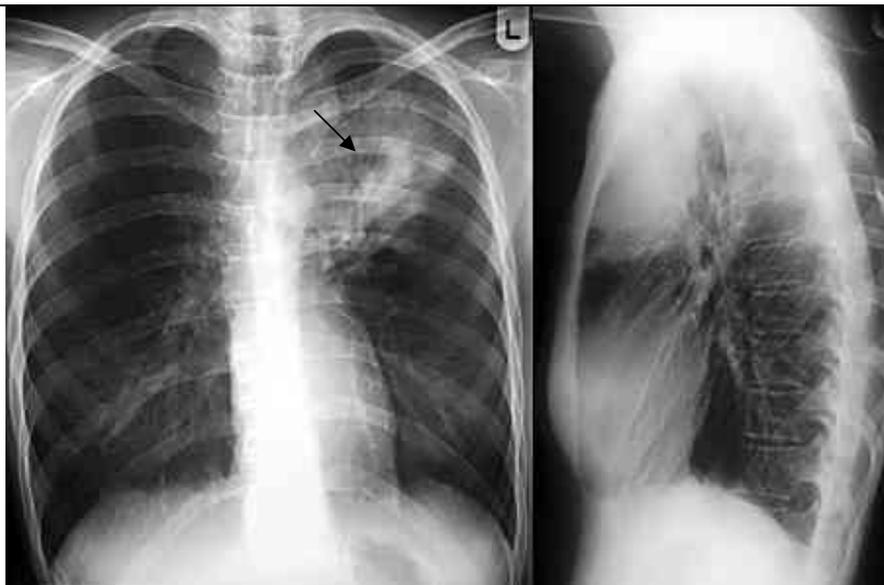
Survey radiograph in frontal and lateral projections. Extensive shadowing of left pulmonary field, air bronchogram (arrows).
